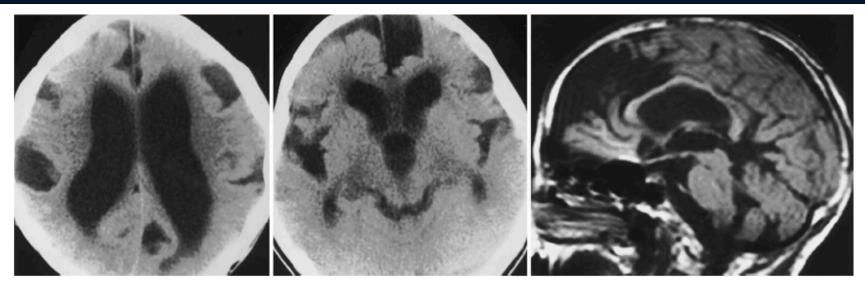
Case 1. Axial CT scans obtained through the bodies of the lateral ventricles (*left*) and the third ventricle (*center*) and a paramidline sagittal T_1 -weighted MR image (*right*) (TR 600 msec, TE 15 msec) demonstrating marked dilation of the lateral ventricles. The third ventricle is severely dilated and rounded. The fourth ventricle is also dilated. Evaluation of the sulci demonstrates marked dilation of the following sulci: the sylvian fissures bilaterally, the central sulci bilaterally, the anterior aspect of the interhemispheric fissure, the left parietooccipital fissure, and the left calcarine fissure. In addition, there is marked focal dilation of the sulcus cinguli on the right side, the precentral sulcus on the left side, and the frontal sulci bilaterally. There is also dilation of the suprasellar and quadrigeminal plate cisterns. The remaining sulci are compressed. The sagittal MR image demonstrates thinning and upward bowing of the corpus callosum. More caudal images demonstrated a moderate dilation of the temporal horns of the lateral ventricles; however, there is no evidence of dilation of the choroidal and parahippocampal fissures, hippocampal atrophy, or cerebellar or brainstem abnormalities.
